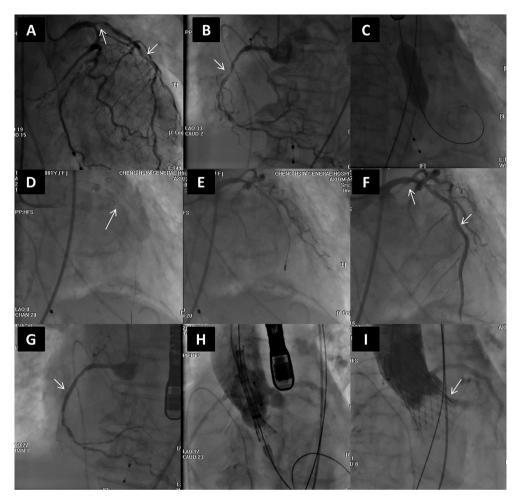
Patient #2. (A) Coronary angiography showing left main disease and LAD artery stenosis before rotablation and stenting (arrows); (B) coronary angiography showing right coronary artery stenosis before stenting (arrow); (C) BAV before PCI; (D) failure to cross the lesion of the proximal LAD with an intravascular ultrasound catheter because of marked calcification (arrow); (E) rotablator burr crossing the left main and LAD lesions; (F) coronary angiography showing left main and LAD after rotablation and stenting; (G) coronary angiography showing RCA after stenting; (H) implantation of a 26 mm MCV prosthesis; (I) final angiography showing mild aortic regurgitation after MCV implantation (arrow). BAV = balloon aortic valvuloplasty; LAD = left anterior descending; MCV = Medtronic CoreValve; PCI = percutaneous coronary intervention; RCA = right coronary artery.
